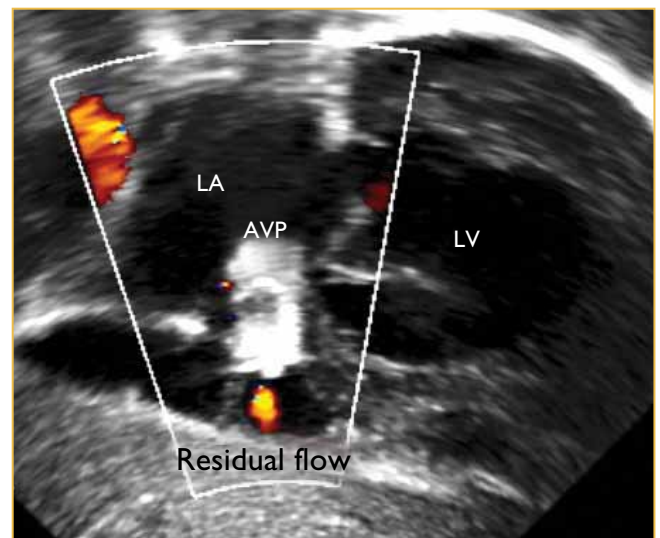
Transthoracic echocardiography of the CAF with the Amplatzer® AVP2 in situ. The red colour Doppler signal below the plug (AVP) indicates a small amount of residual flow through the plug.
